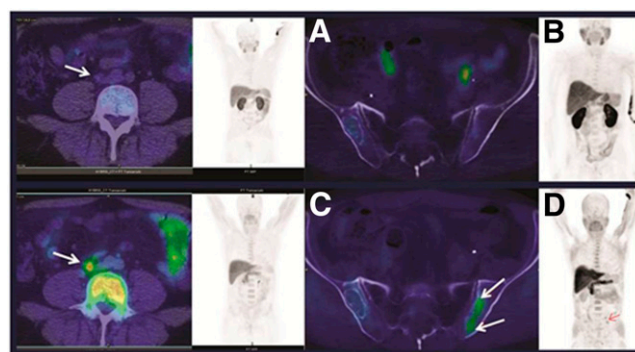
^{18}F -FACBC and ^{11}C -choline PET/CT in patients with radically treated prostate cancer and biochemical relapse. Left block: images acquired with ^{11}C -choline (top) and ^{18}F -FACBC (bottom). The right common iliac lymph node (arrows) was negative on choline imaging but positive with ^{18}F -FACBC. Right block: images acquired with ^{11}C -choline (top) and ^{18}F -FACBC (bottom). The left sacroiliac joint (arrows) was negative on choline imaging but positive with ^{18}F -FACBC.
